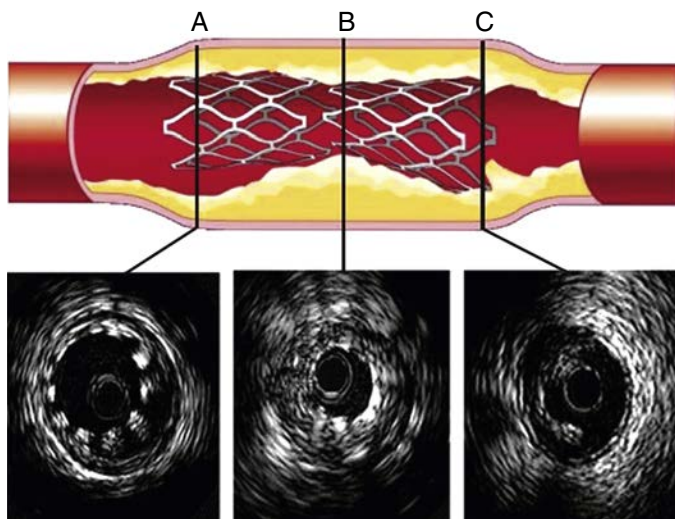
e1 Intravascular ultrasound (IVUS) images of stent deployment complications. Cross-sectional IVUS images of complications following stenting: (A) stent malapposition (i.e., gap between the stent and vessel wall); (B) stent under-expansion; and (C) edge dissection. (Adapted from *Vascular Disease Management*, Buckley CJ: *Intravascular ultrasound is critical to insuring long-term stent performance*. 2006. <http://www.vascular-disease-management.com/content/intravascular-ultrasound-critical-insuring-long-term-stent-performance>. Accessed April 1, 2015.)
